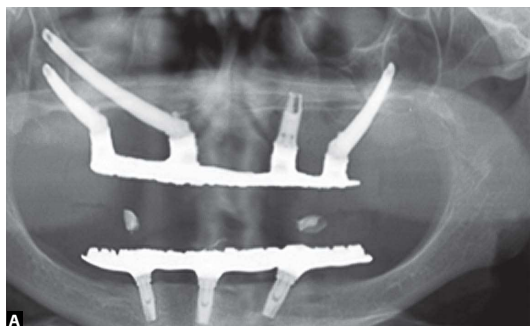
Current clinical aspect and personal satisfaction with follow-up 5 years after fixed rehabilitation; control panoramic radiograph obtained every year after rehabilitation.
